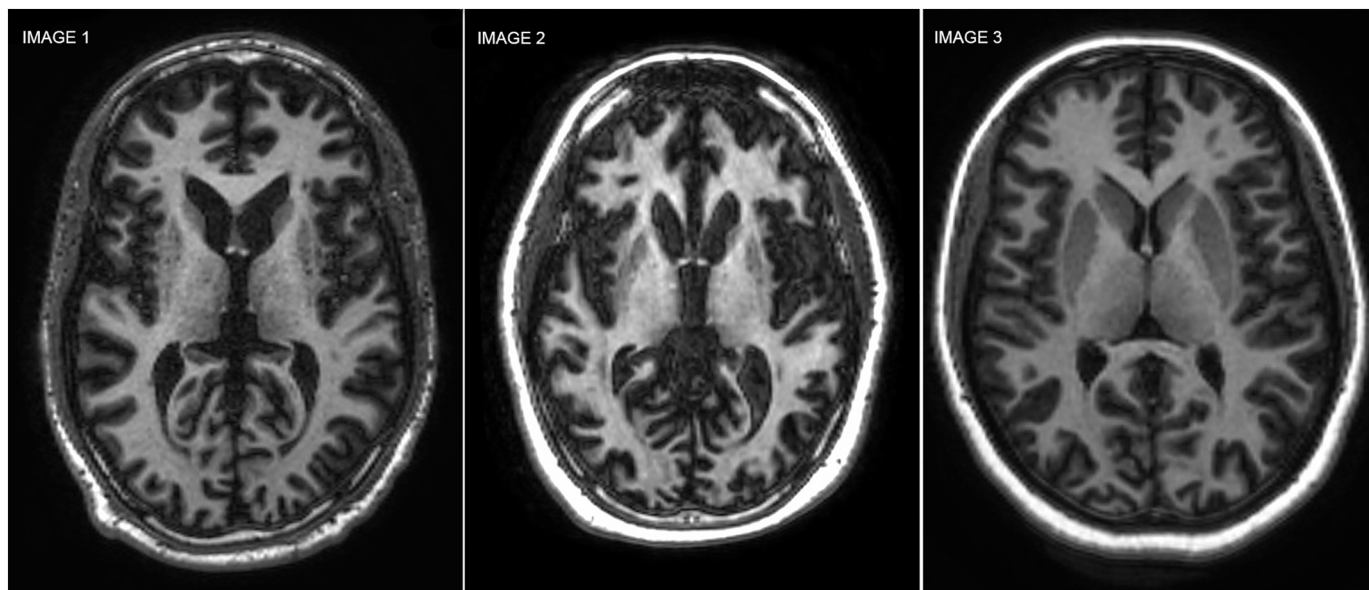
Qualitative MRI Comparison. Three T1 axial 1.5 T MRIs comparing HDL2, HD and a normal control case. Image 1: 35-year-old HD subject with abnormal *HTT* allele = 49 triplet repeats. Image 2: 32-year-old HDL2 subject with abnormal *JPH3* = 53 triplet repeats. Image 3: 32-year-old normal control subject. The HDL2 and HD subjects show qualitatively similar grey and white matter atrophy with caudate nuclei and putaminal volume loss compared to the normal control.
